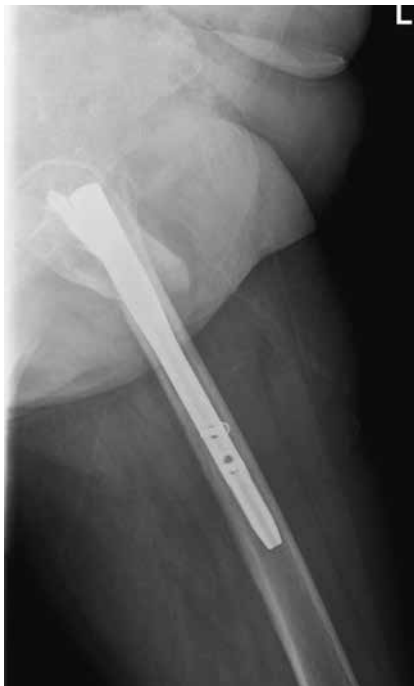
Post-operative lateral radiograph of the left hip.
